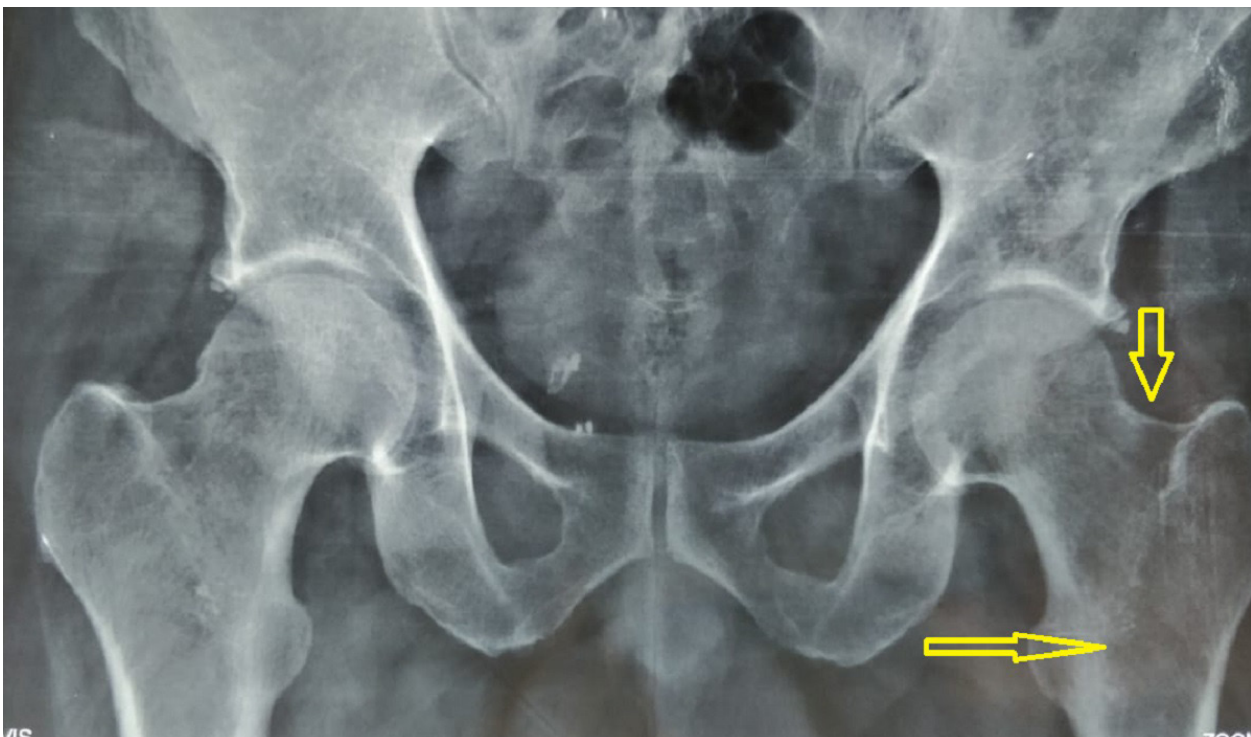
Radiograph of the pelvis anteroposterior view showing the diffuse osteoporosis in the left proximal femur including head, neck, trochanteric region (arrows)
